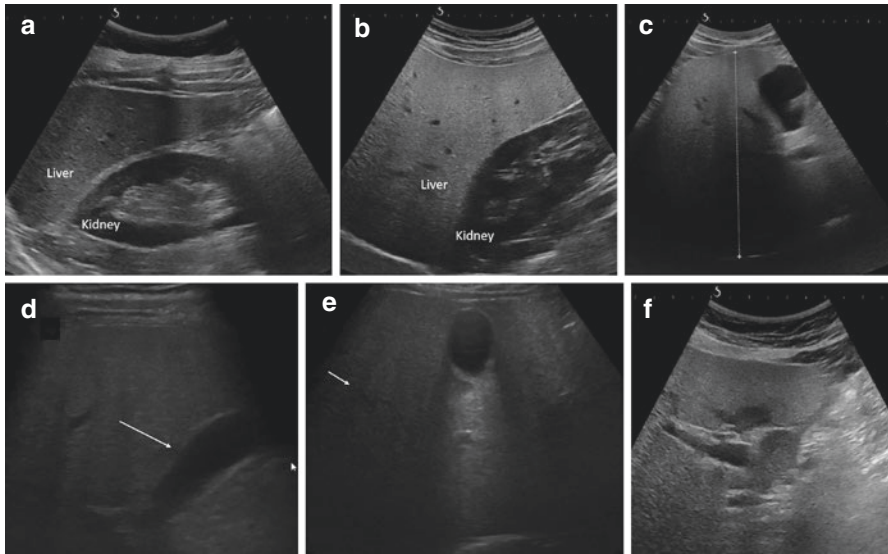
Typical aspect of liver steatosis on ultrasound. Panel (a): Mild steatosis: diffuse hyper-echogenic aspect of the liver with slightly increased liver/kidney echogenicity ratio. The intrahepatic vessels are well visible. Panel (b): Moderate steatosis: diffuse and homogeneous hyperechogenic “bright” aspect. Notice the clearly increased liver/kidney echogenicity ratio. Panel (c): Severe steatosis; enlarged liver with attenuation of the ultrasound beam that exceeds the posterior half of the right lobe. Panel (d): Steatosis with blurring of the gallbladder wall (arrow). Panel (e): Steatosis with blurring of the intrahepatic vessels (arrow). Panel (f): Area of focal sparing (arrow) can be identified as a zone of normal echogenicity within a bright liver. Most common sites include perivesicular and periportal location (such as in the present case)
